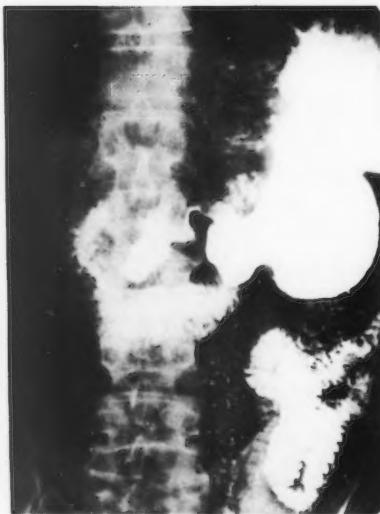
P.C. Gastrointestinal roentgenographic series revealed an annular constriction in the prepyloric area of the stomach.
